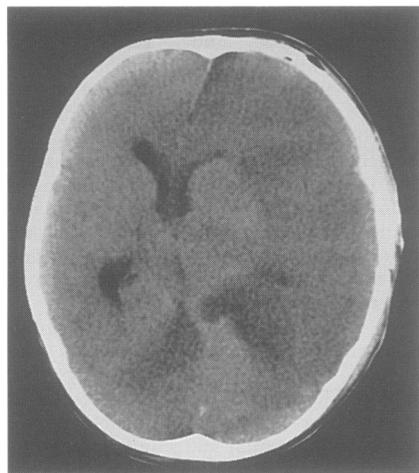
Brain CT of head on admission showing mass effect and midline shift.
